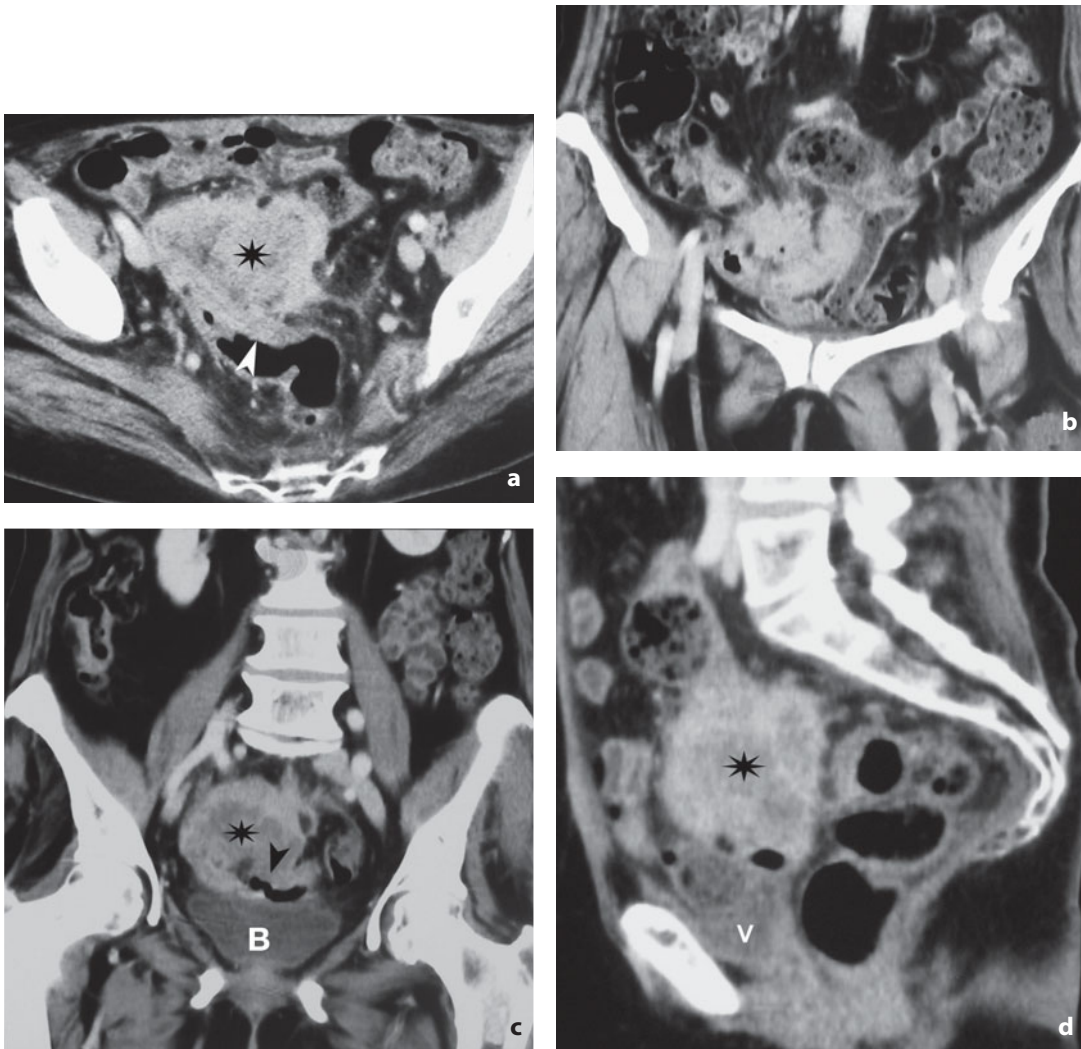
Computed tomography. Recurrence of endometrial cancer. Appearance after radical hysterectomy. Axial image (a), coronal (b, c) and sagittal reconstructions (d). Large solid and heterogeneous mass with irregular margins (*asterisk*) can be identified in the centre of the pelvis above the rectouterine pouch infiltrating the sigmoid colon (*arrowhead*). B, urinary bladder
